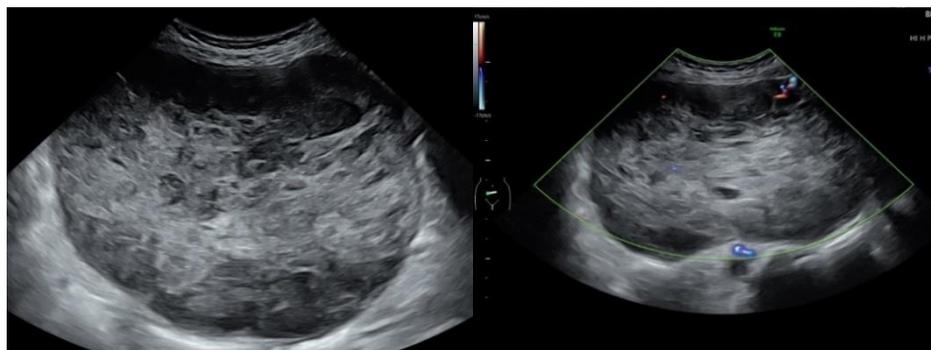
Atypical solid uterine leiomyosarcoma mimicking fibroid with mixed echostructure at gray-scale imaging (A) and at color Doppler where only scant peripheral vascularity could be seen (B)
